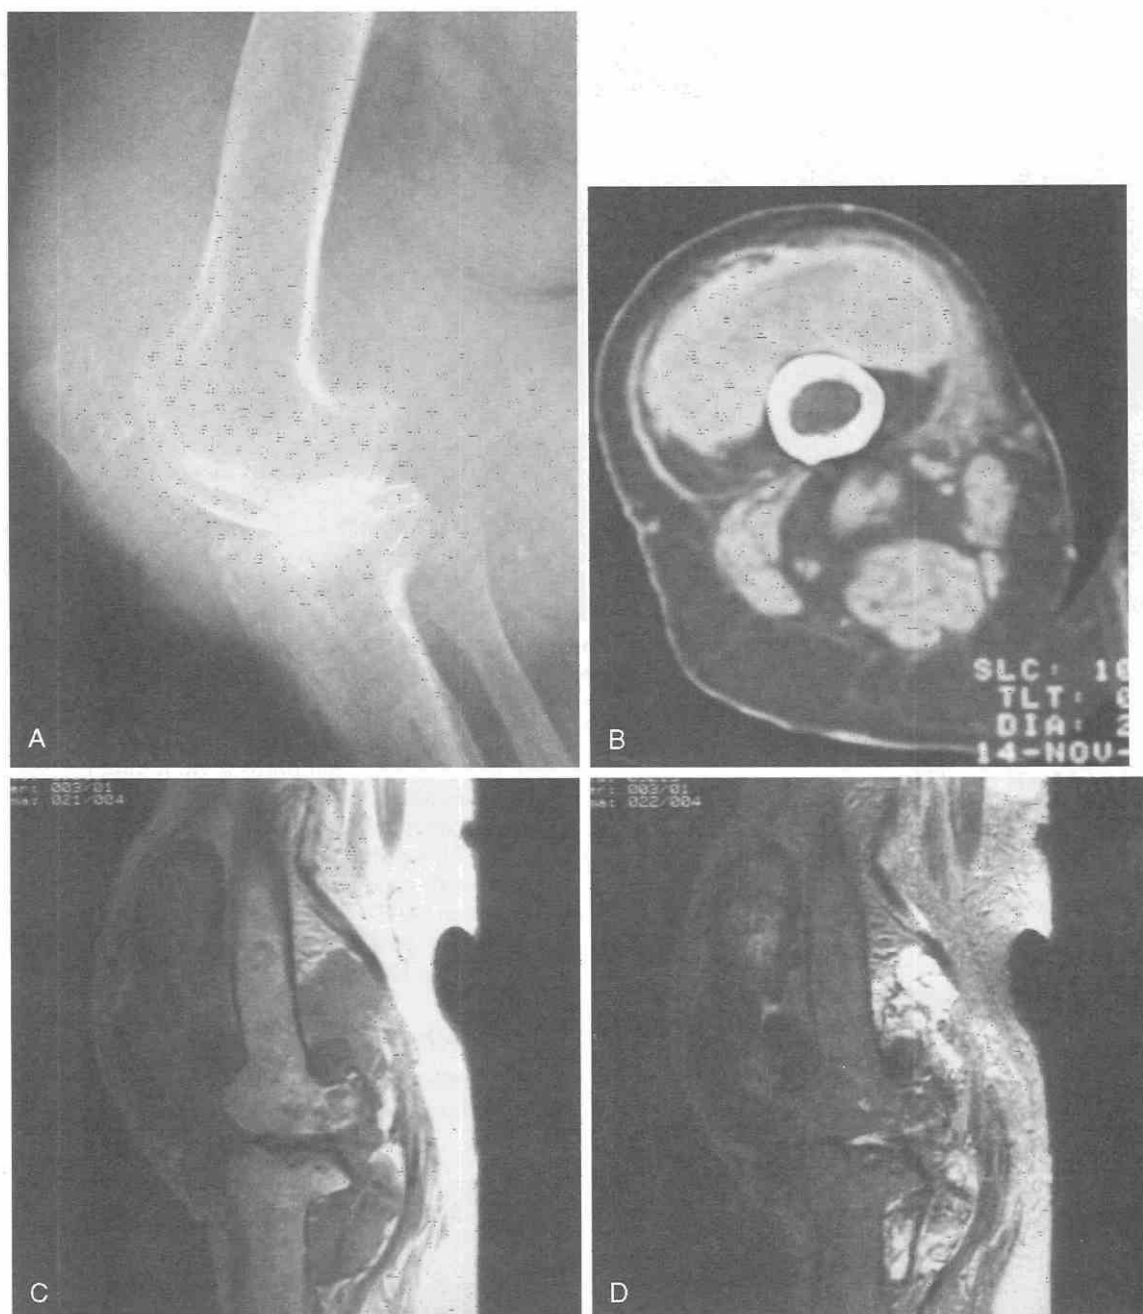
Pigmented villonodular synovitis (PVNS). *A*, Lateral radiograph shows marked soft tissue prominence within the joint capsule associated with osseous erosions. *B*, Axial CT scan shows mixed attenuation fullness at the suprapatellar bursa. *C* and *D*, Sagittal proton-density-weighted images and T2-weighted images show the extent of the mixed-signal mass within the joint. Persistent low signal areas on both sequences, especially those at the capsular margins, indicate extensive hemosiderin deposition and a probable diagnosis of PVNS.
